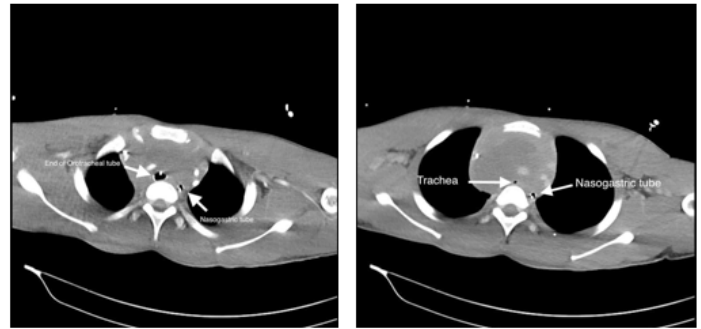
Axial computed tomography of chest. (A) shows the tube in the trachea. (B) shows extrinsic airway compression of the trachea below the tube (nasogastric tube).
